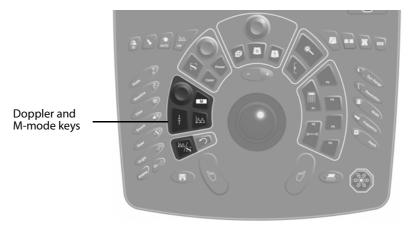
The Doppler and M-mode keys on the control panel.
